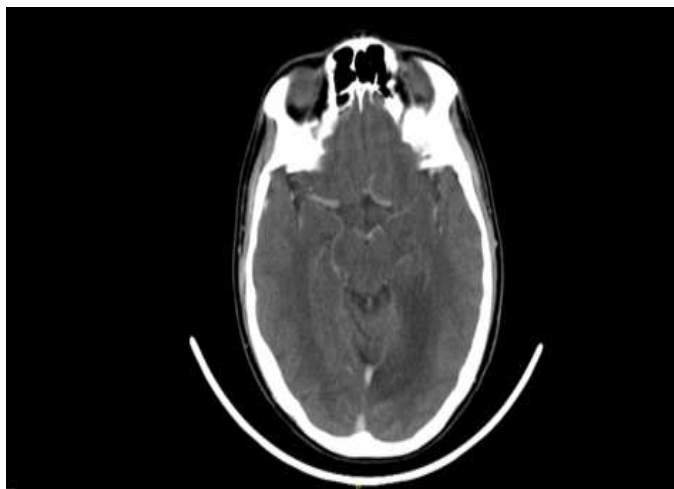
CT brain with contrast showed: development of hypodensity in medial temporal region on the left side acute infarction
